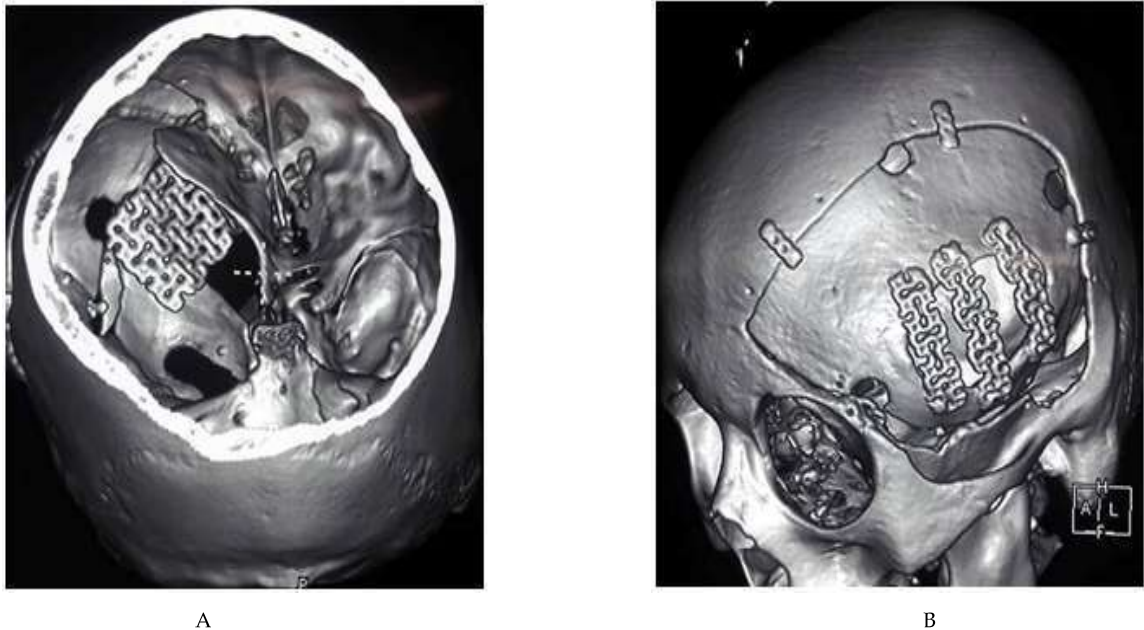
CT scan of brain 3D reconstruction showing, reconstruction of the orbital roof (A) and calvarial defect (B) with titanium mesh.
